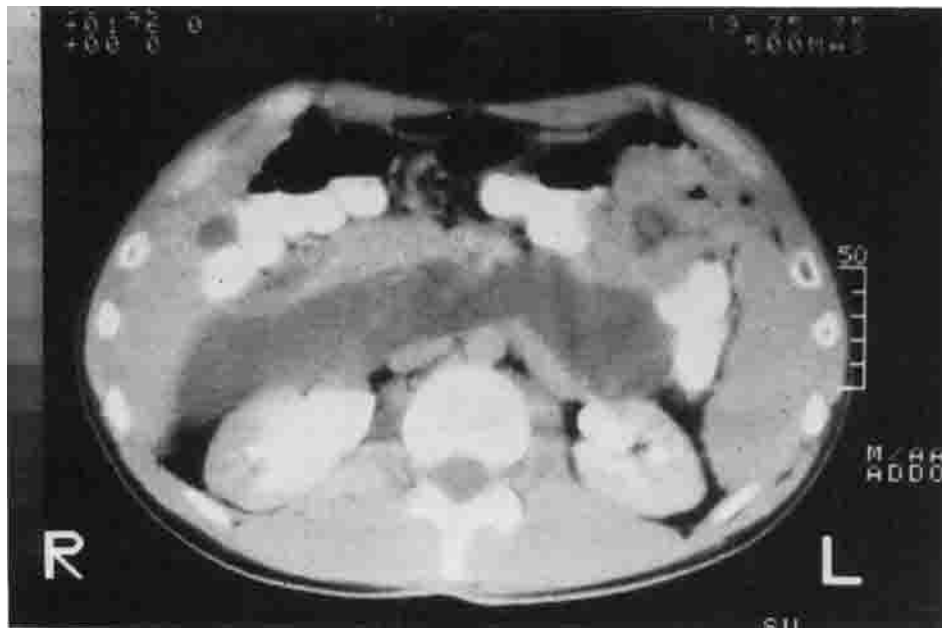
The retroperitoneal position of a cystic and cavernous lymphangioma (Case 1) is shown. The CT scan disclosed pancreatic dislocation, inferior vena cava compression, and adhesion to the right vena cava. The left colon is anteriorly displaced.
